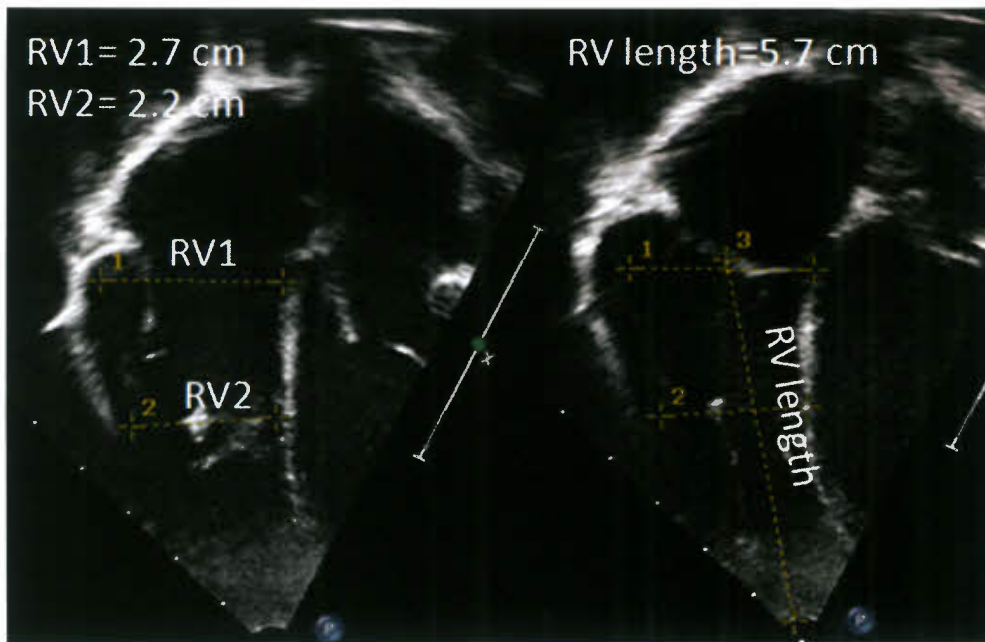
Measurement of right ventricular (RV) 2-D dimensions. From the apical four-chamber view, RV width is measured just below the tricuspid valve (RV1) and in the mid part of the RV (RV2). RV length is also measured just after tricuspid valve closure from the mid of the tricuspid valve to the apex of the RV.
